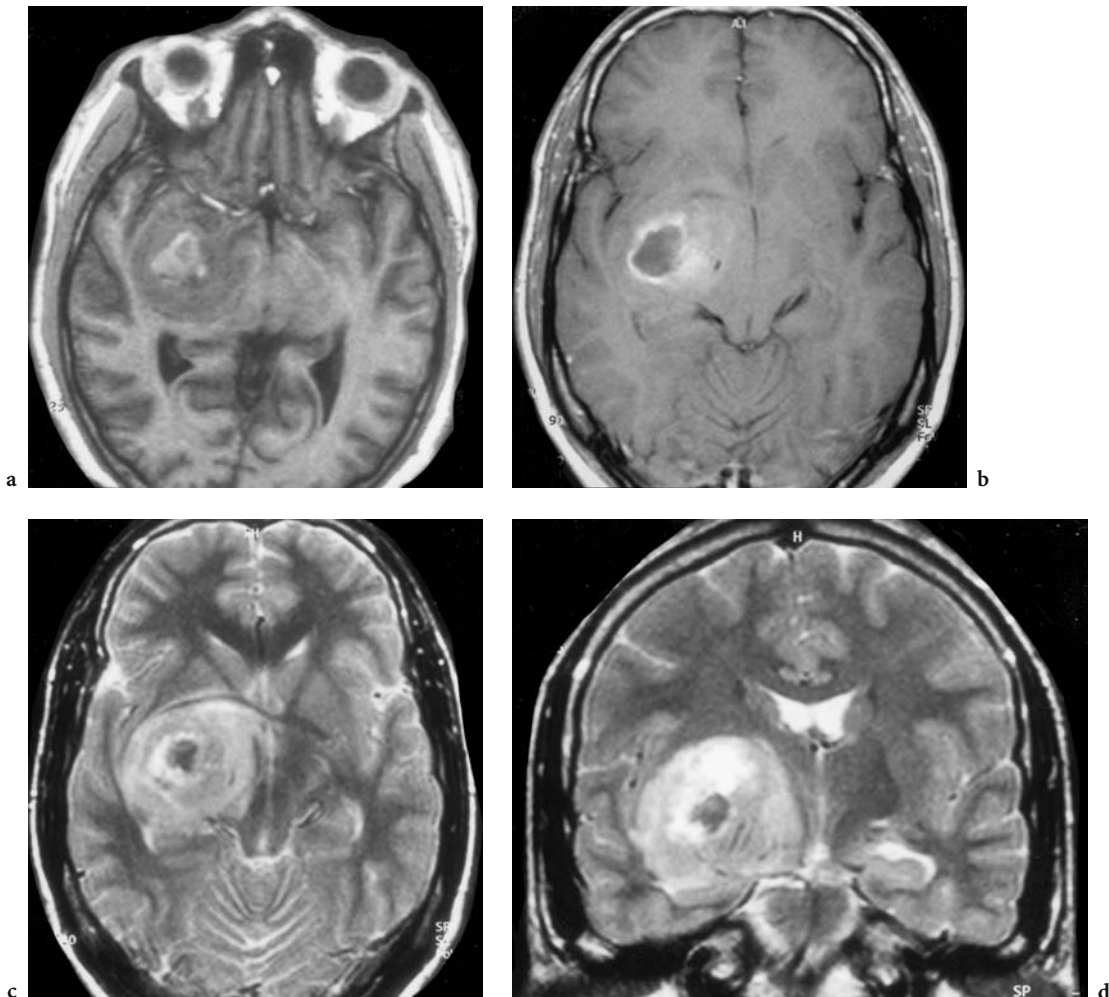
A 20-year-old man with left hemiparesis and hemianopia to the left. Diagnosis: ependymoma WHO II–III with spontaneous intratumoral hemorrhage. MRI: a Axial T1-weighted native view (3D-data set) showing a round, iso- to hypointense lesion with central cockade-shaped hyperintensity in the right basal ganglia, indicating the presence of subacute hemorrhage. b Axial, T1-weighted (tilted orbito-meatal), contrast-enhanced view with superior demonstration of the tumor location in the basal ganglia and BBB disruption of the solid tumor. c Corresponding T2-weighted image, with superior demonstration of the interruption of the fibers of the optic tract to the lateral geniculate nucleus, interrupted by the mass, which dislocates the anterior commissure. d Coronal T2-weighted view. Note, identical to c, the characteristic signal of acute (hypointense) to subacute (hyperintense) hemorrhage (also hyperintense on the T1-weighted image)
